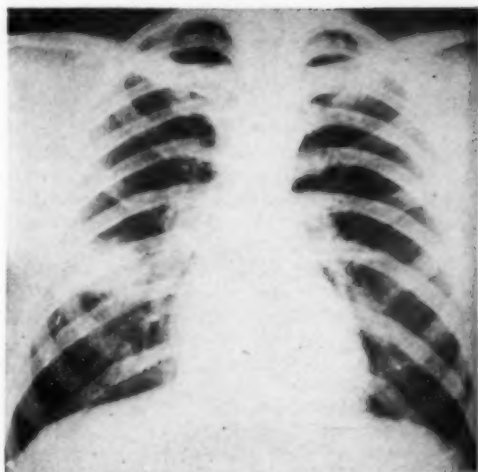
Case 1 (A. D.): Two months after admission, roentgen examination showed consolidation on the right definitely undergoing resolution.
